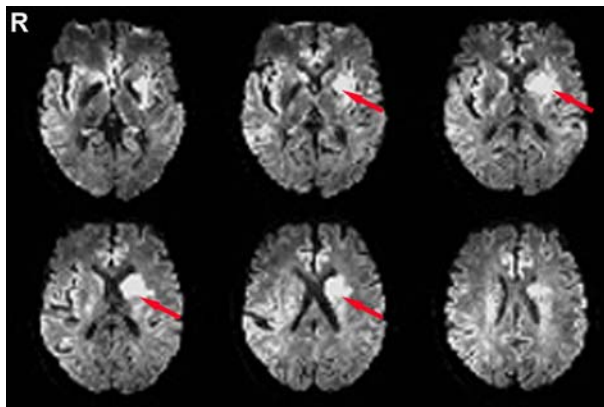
DWI in acute ischemic stroke: the area with higher signal intensity (red arrow) indicates the infarct core.
